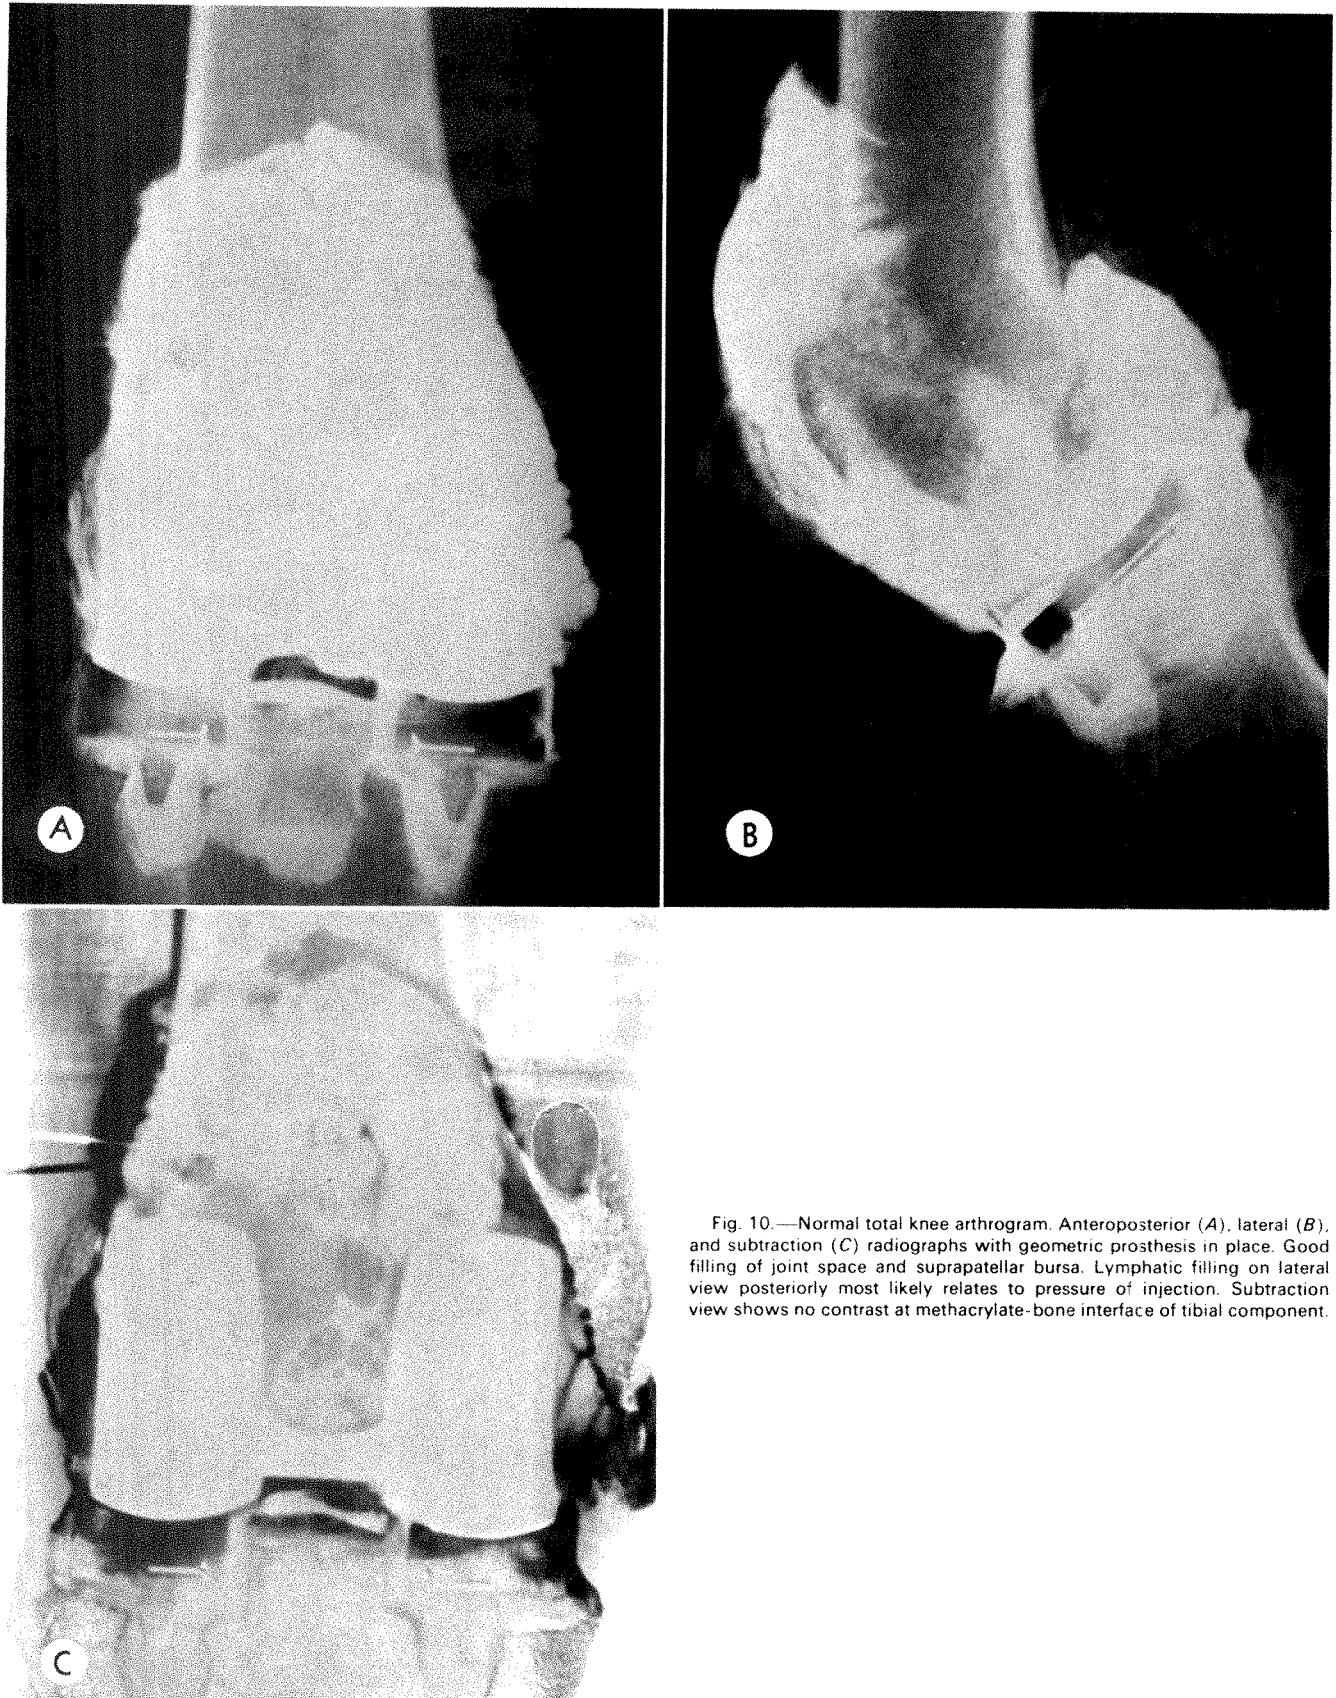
Normal total knee arthrogram. Anteroposterior (A), lateral (B), and subtraction (C) radiographs with geometric prosthesis in place. Good filling of joint space and suprapatellar bursa. Lymphatic filling on lateral view posteriorly most likely relates to pressure of injection. Subtraction view shows no contrast at methacrylate-bone interface of tibial component.
